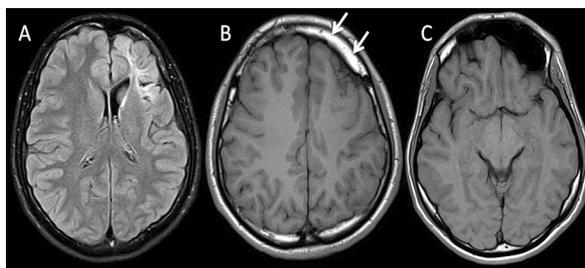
T2W FLAIR image in the axial plane (A) showing atrophy of the left frontal lobe with gliosis of subcortical and deep frontal white matter as well as “ex vacuo” widening of the extracerebral CSF spaces and frontal horn of the left lateral ventricle. Thickening of the squama of the frontal bone is evident on the T1W axial image (arrows in B) and shift of midline structures toward the left. T1W image in the axial plane (C) shows hyper-pneumatization of the left frontal sinus. Decreased volume of the left anterior cranial fossa is visible on all three images.
